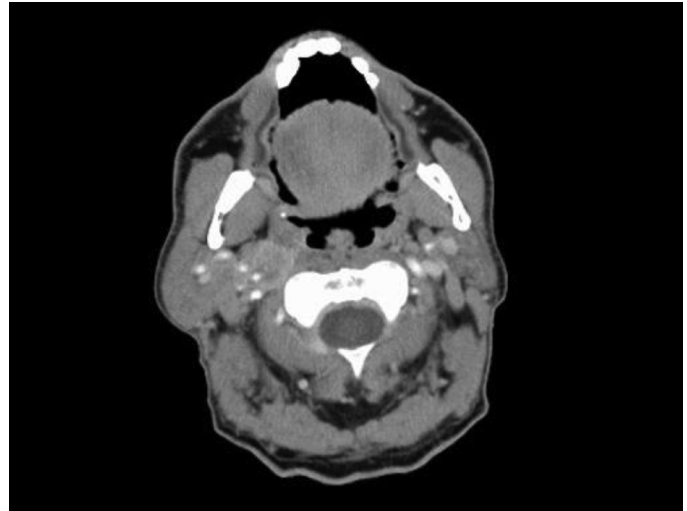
Cervical computed tomography with contrast shows contrast-enhanced pathologic lymph nodes in the right retropharyngeal area obliterating the right carotid artery.
